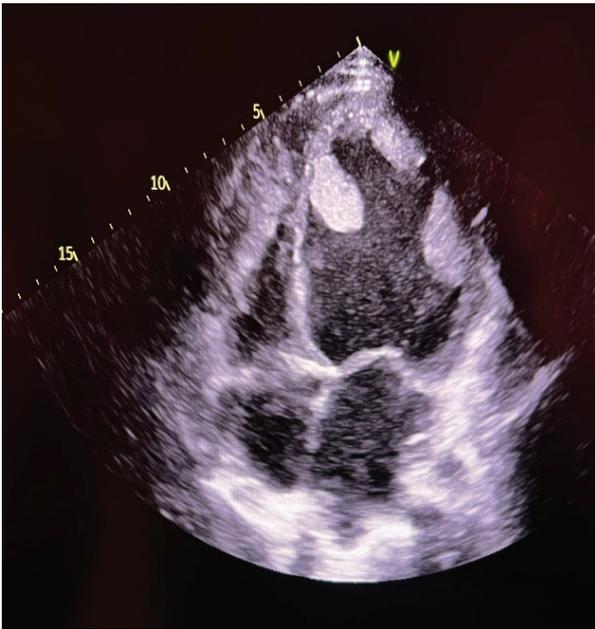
Transthoracic echocardiogram showing hypo-echoic masses concurrent with biventricular multiple thrombi.
